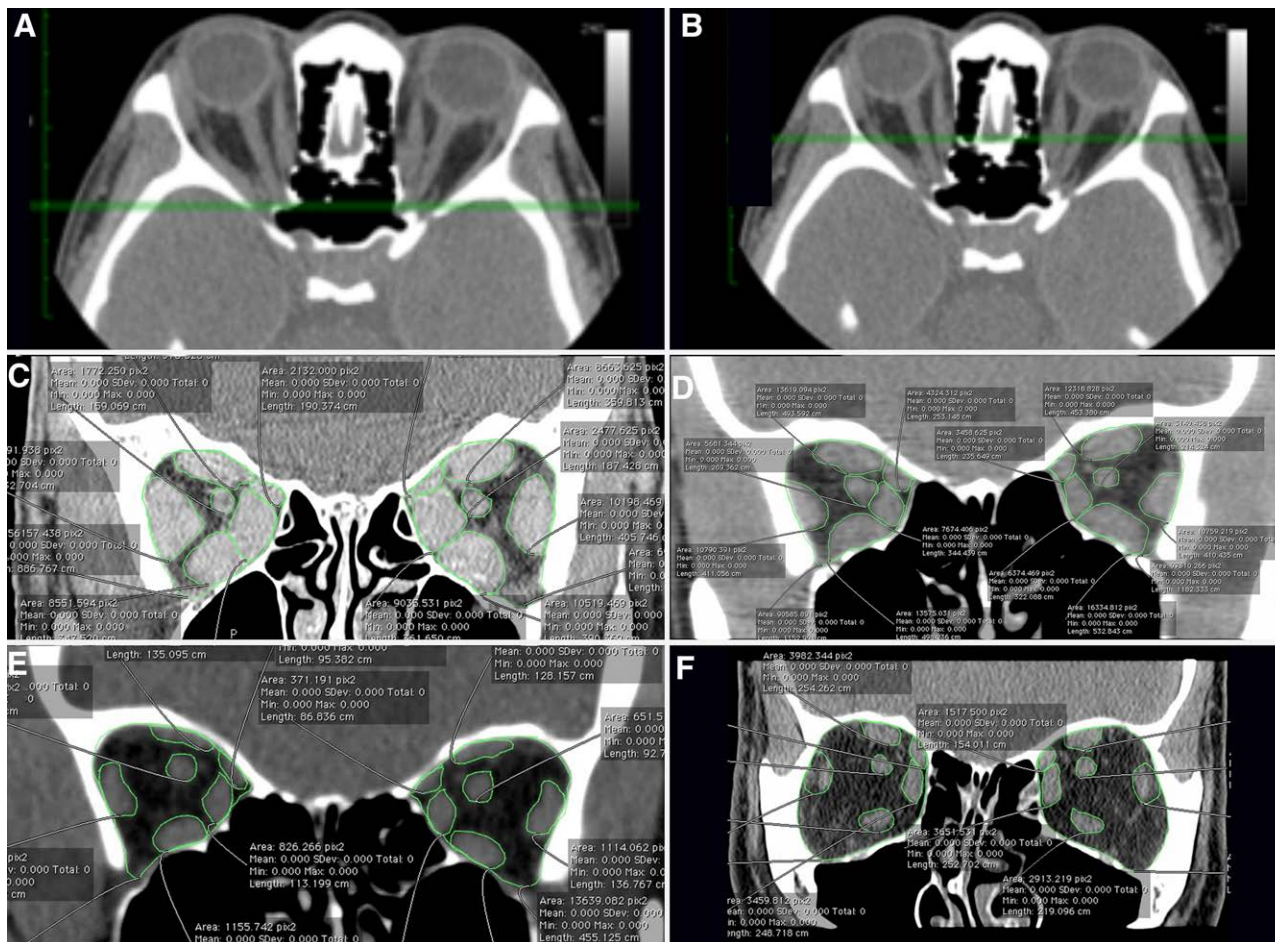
Contouring analysis. Axial and coronal CT soft tissue images are linked within the viewer. In the axial plane, the anterior border of the superior orbital fissure (SOF) is identified as the initial reference point (A, horizontal green line). Next, a point 15 mm ± 2 mm anterior to the SOF in the axial plane is identified (B, horizontal green line). In the corresponding coronal image, extraocular muscles (EOMs) and optic nerves are manual traced for various fat to orbit ratios (C) >75% fat, (D) 50%–75%, (E) 25%–50%, and (F) <25%. All measurements were done using OsiriX Imaging Software. [full color online](#)
